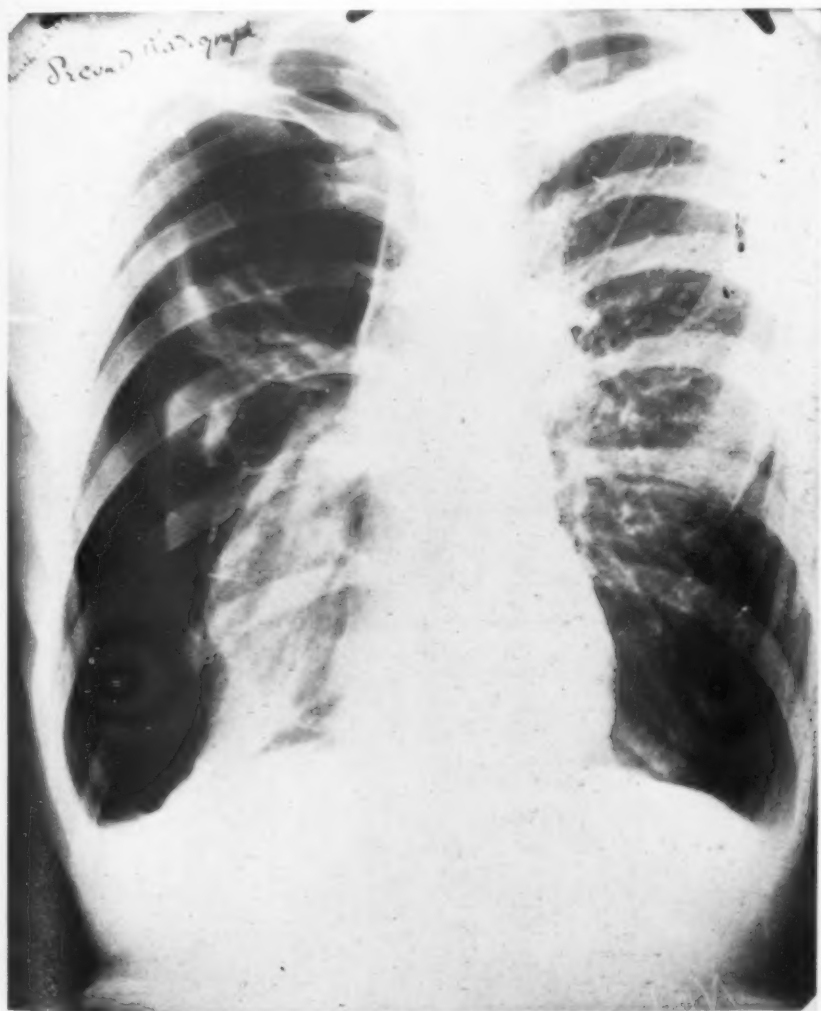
Radiograph of Case No. I three weeks after pneumothorax.
